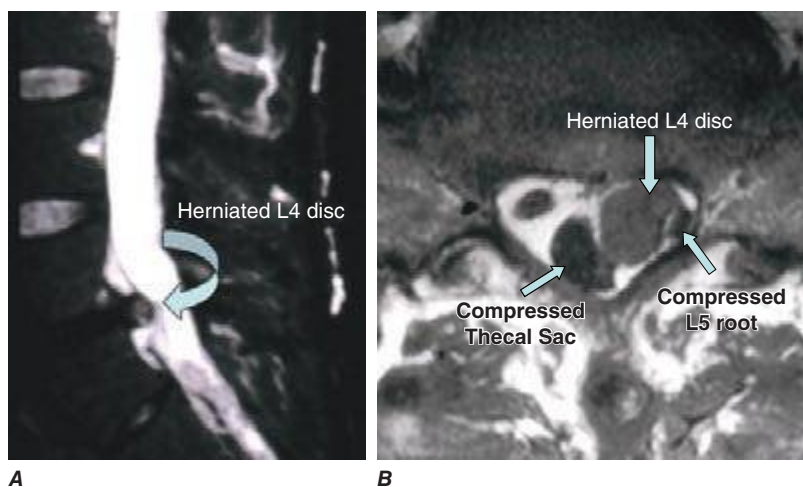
Left L5 radiculopathy. A. Sagittal T2-weighted image on the left reveals disk herniation at the L4-L5 level. B. Axial T1-weighted image shows paracentral disk herniation with displacement of the thecal sac medially and the left L5 nerve root posteriorly in the left lateral recess.
